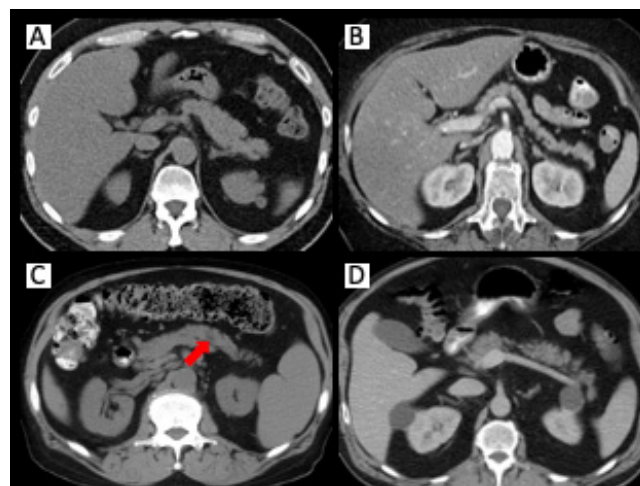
Sample axial view of the pancreas in CT images. (A) Control CT image without contrast. (B) Control CT image with contrast. (C) Missed PDAC CT image without contrast and the lesion is present in the pancreatic body. (D) Missed PDAC CT image with contrast.
